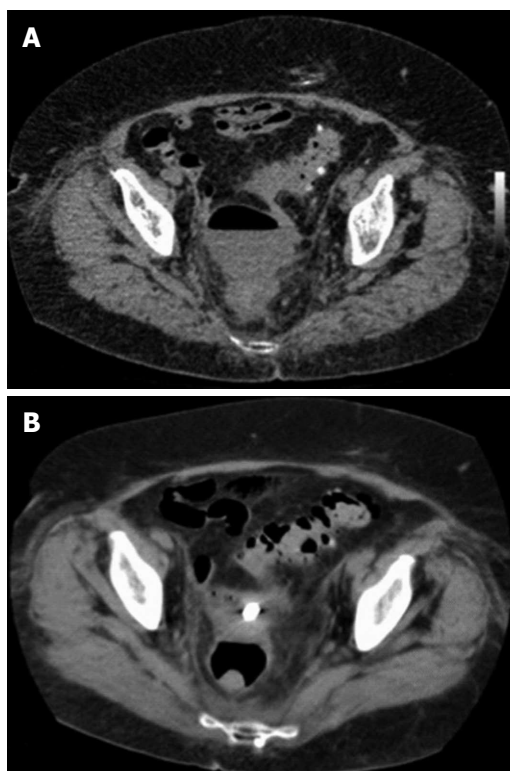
Abdominopelvic computed tomography. A: Before the procedure; B: After the procedure.
